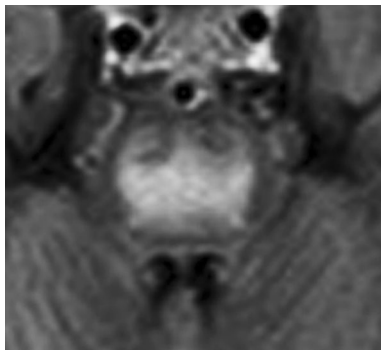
Axial FLAIR showing a central pontine hyperintensity encircling and respecting the pyramidal tracts giving the ODS lesion a wing- or eagle-like aspect
